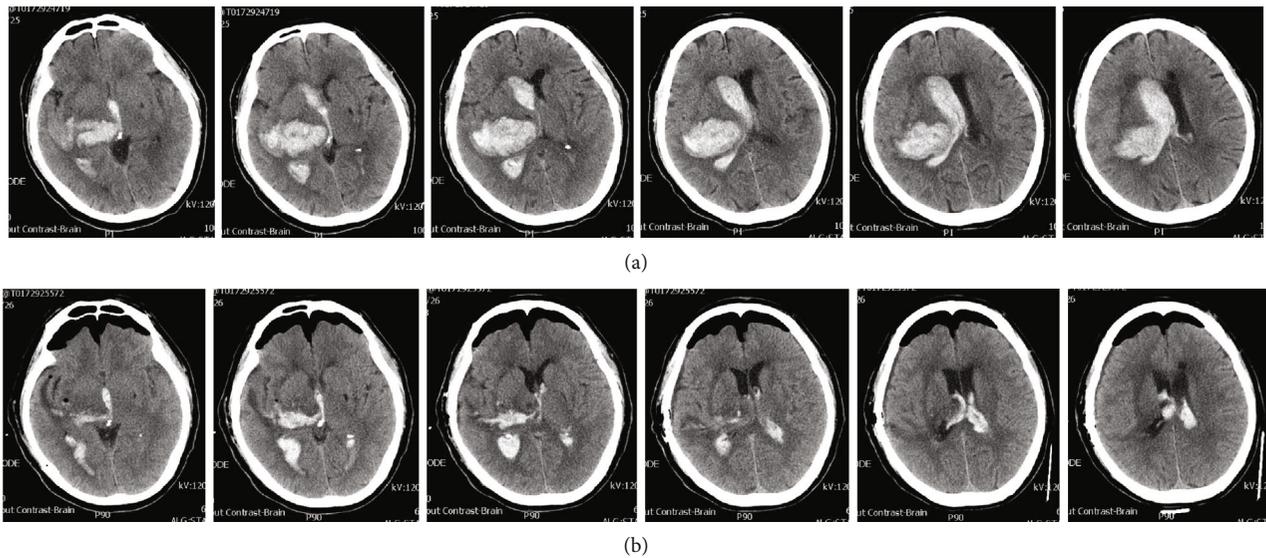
Axial CT scans. (a) Preoperative thalamic hematoma which ruptured into the ventricle. (b) Postoperative residual thalamic hematoma and intraventricular hematoma.
